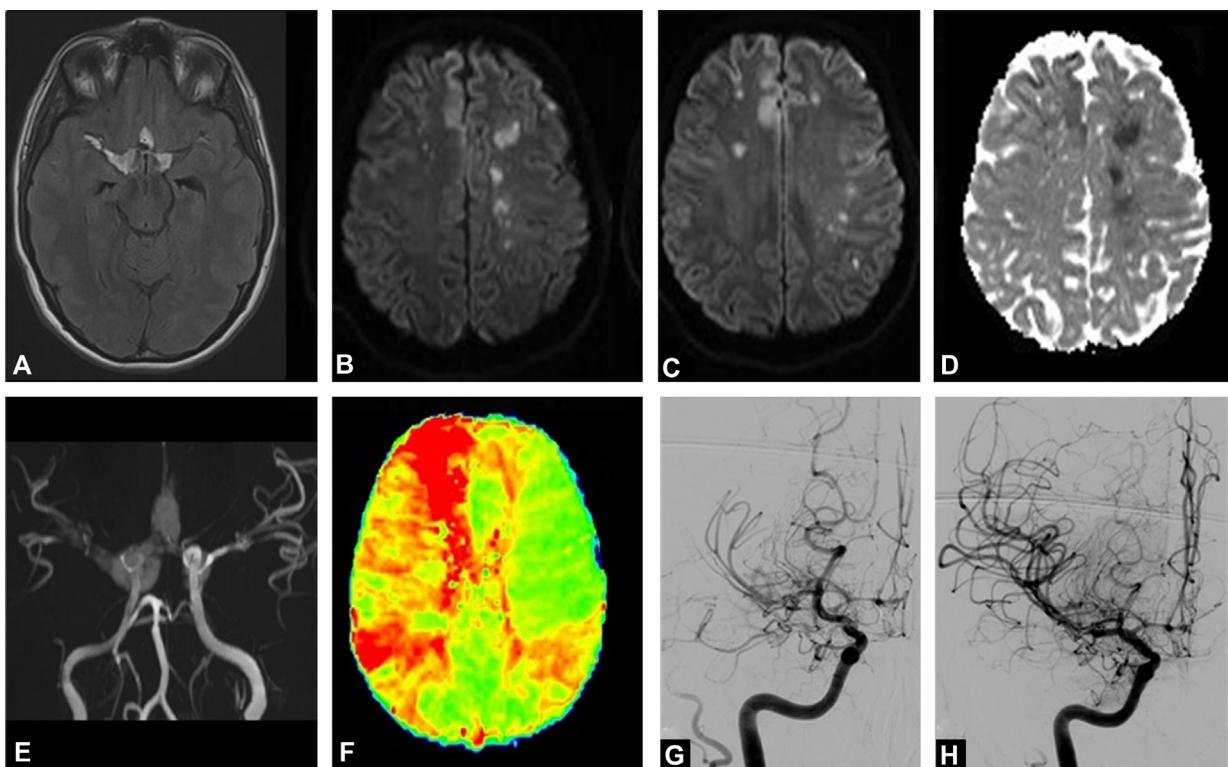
Twenty-nine year old woman presenting with a subarachnoid hemorrhage, initially Fisher grade 3 due to rupture of the anterior communicating artery treated endovascularly (not shown). On D10 she developed a left hemiplegia. Urgent cerebral MRI. Appearance of subarachnoid hemorrhage, hyperintense of FLAIR imaging in the motor cortex sulci (A). Development of bilateral junctional hyperintense b1000 punctiform ischemic lesions (B, C); restriction on ADC mapping (D). Pronounced spasm of the trunks of the carotid arteries and middle and anterior cerebral arteries seen on time of flight imaging of the circle of Willis (E) with large extensive increase in the mean transit time mostly affecting the middle and right anterior cerebral artery territories and the left posterior superficial middle cerebral artery (F). Confirmation of severe spasm of the carotid and middle and right anterior cerebral artery trunks on arteriography performed immediately afterwards (G) and a large improvement in cerebral parenchymography after intra-arterial injection of milrinone (H).
